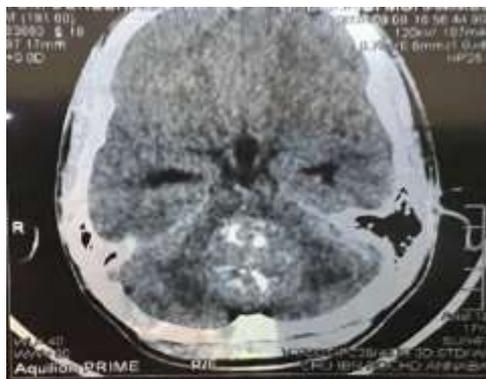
Cerebral CT scan of a PCF ependymoma shows intratumoral calcifications.
